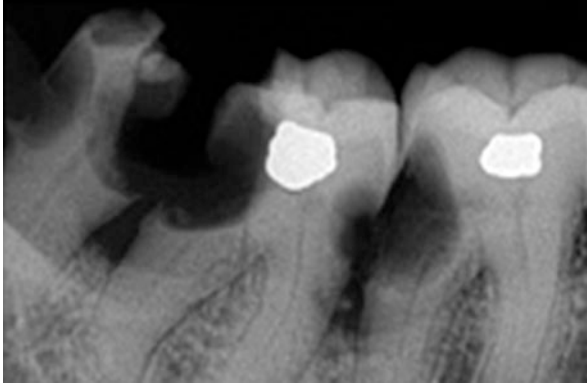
Dental radiograph of the described patient's lower right quadrant, including teeth #29, #30, and #31, exhibiting extensive interproximal caries. The etiology of the dental caries is multifactorial and includes the use of xerostomia-inducing medications, cognitive and physical decline, and poor hygiene associated with the use of dental prostheses. Radiographs such as this are not uncommonly found among elderly patients with dementia
